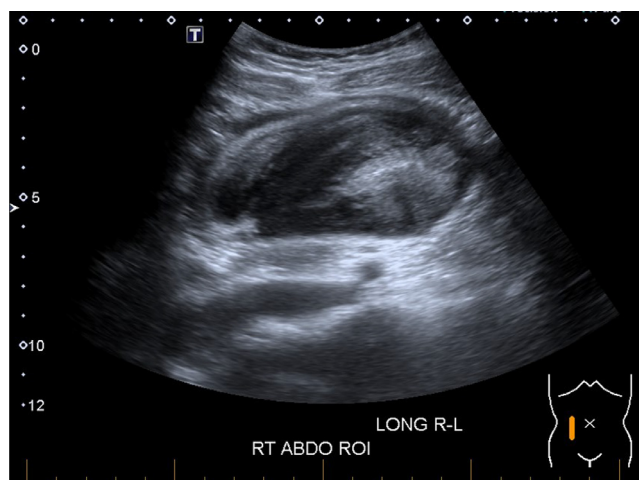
Longitudinal abdominal ultrasound of right lower abdominal lesion with moderate amount of debris seen within. No surrounding free fluid is observed.
